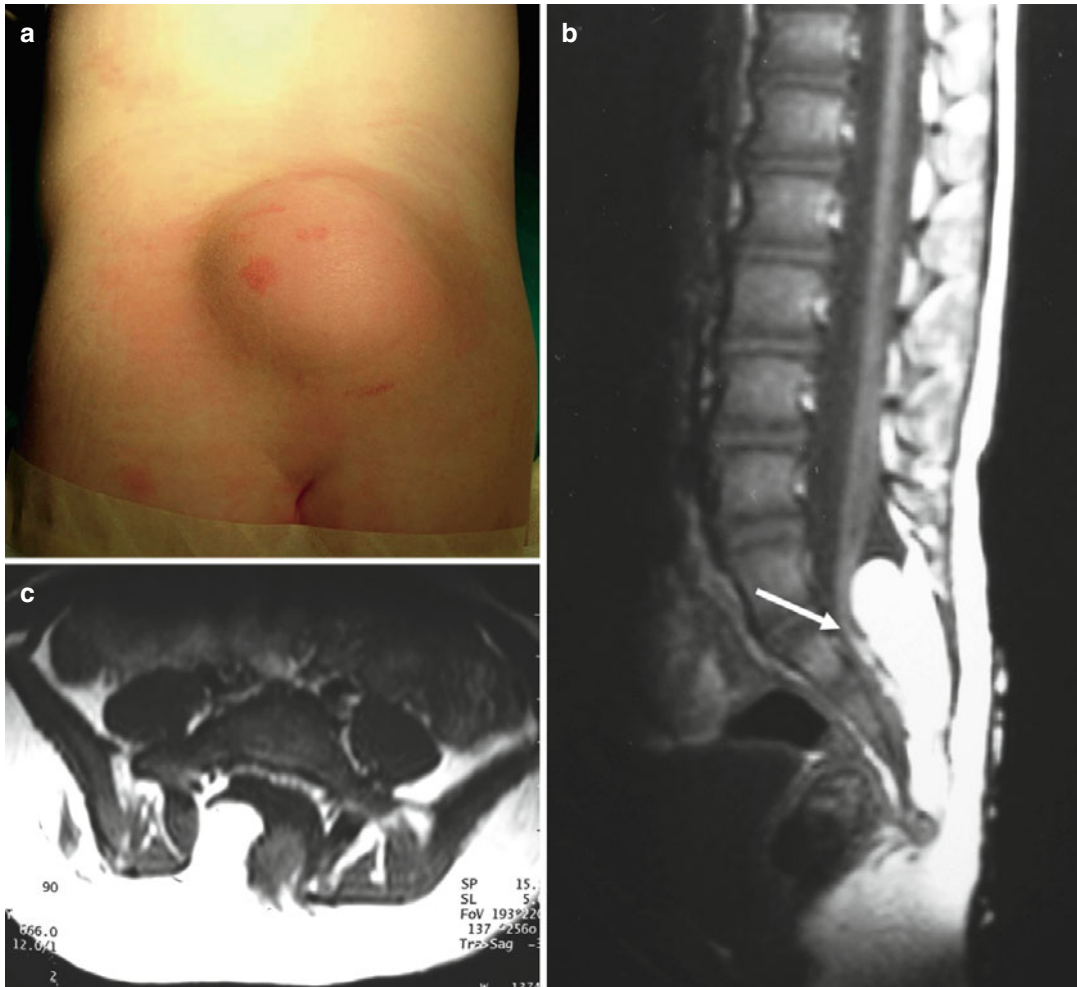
(a) Lipomyelomeningocele in a 2-year-old girl. (b) Sagittal T1-weighted image reveals a fatty mass attached to conus where conus (*arrow*) lies at almost S1
